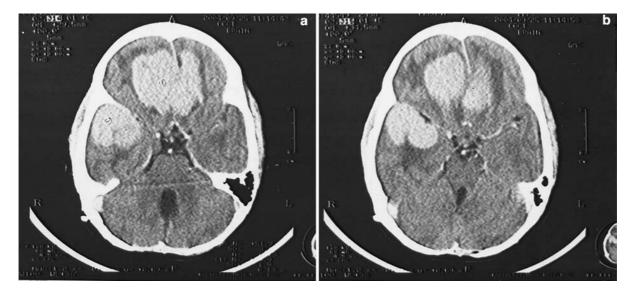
(a) and (b) CT Scan showing multiple solid homogenously enhancing space occupying lesion in bilateral basifrontal and right basitemporal region.
